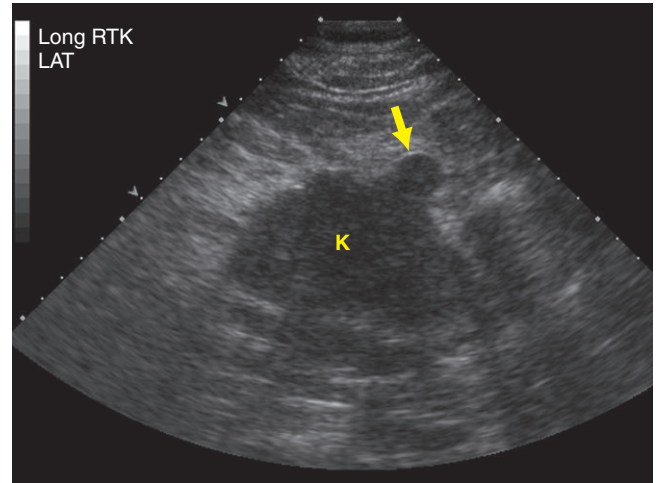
Real-time ultrasound of the right kidney (K) demonstrates circumscribed hypoechoic mass (arrow) with slightly echogenic margins.
